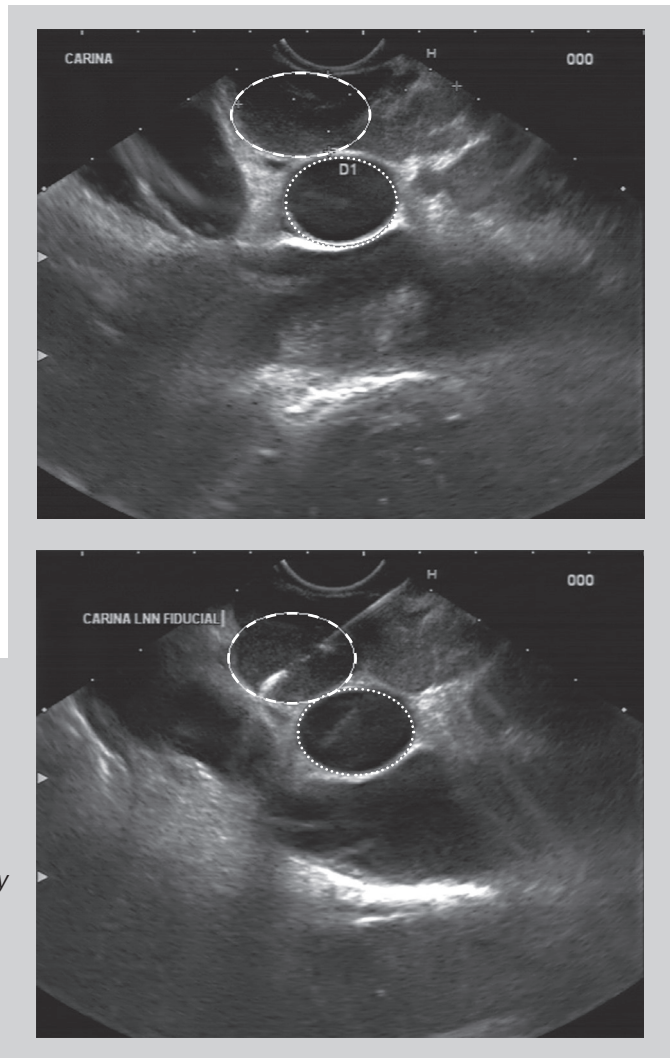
Marker placement under endoscopic ultrasound guidance.
